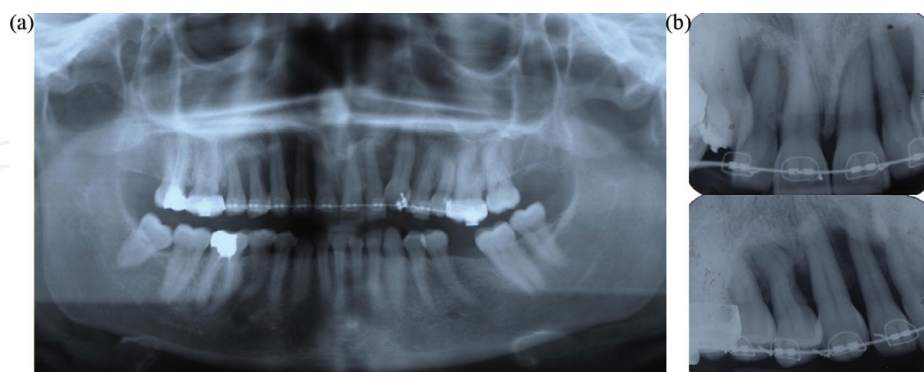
Twenty-two-year-old female patient having a fixed orthodontic appliance for 2 years. She was referred to us by an orthodontist who after one year of orthodontic therapy realised the gravity of the periodontal situation after performing a panoramic radiograph. The orthodontist refused to remove the orthodontic appliance, afraid that the patient would lose the teeth, being retained in their position only through the ligation to the archwire. (a) Panoramic radiograph showing the extensive bone loss in almost all maxillary teeth. (b) Periapical radiographs indicating the almost complete loss of periodontal support for multiple maxillary teeth.
